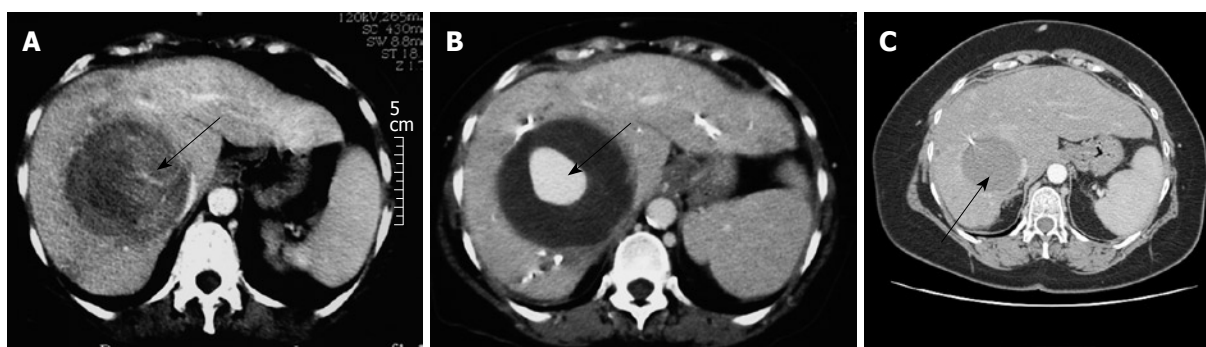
Enhanced CT scan. A: Showing an eighty millimetre HCC (black arrow) developed in the right hepatic lobe, driving back the median hepatic vein, in contact with the right glissonian pedicle; B: Showing an arterial aneurysm (black arrow) due to the main tumour artery traumatism during biopsy; C: Showing complete tumour necrosis after combined portoarterial embolization (black arrow).
